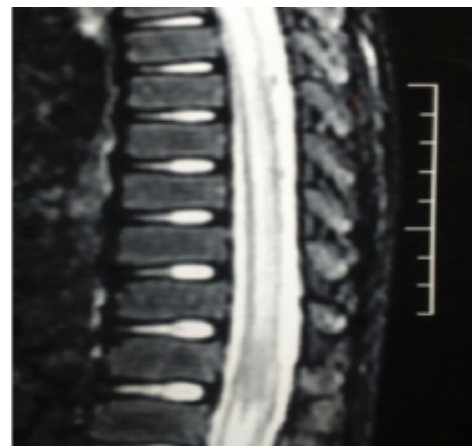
MRI (T2 image) of cervico-dorsal spinal cord showing long segment intramedullary hyperintensities (long segment myelitis)
